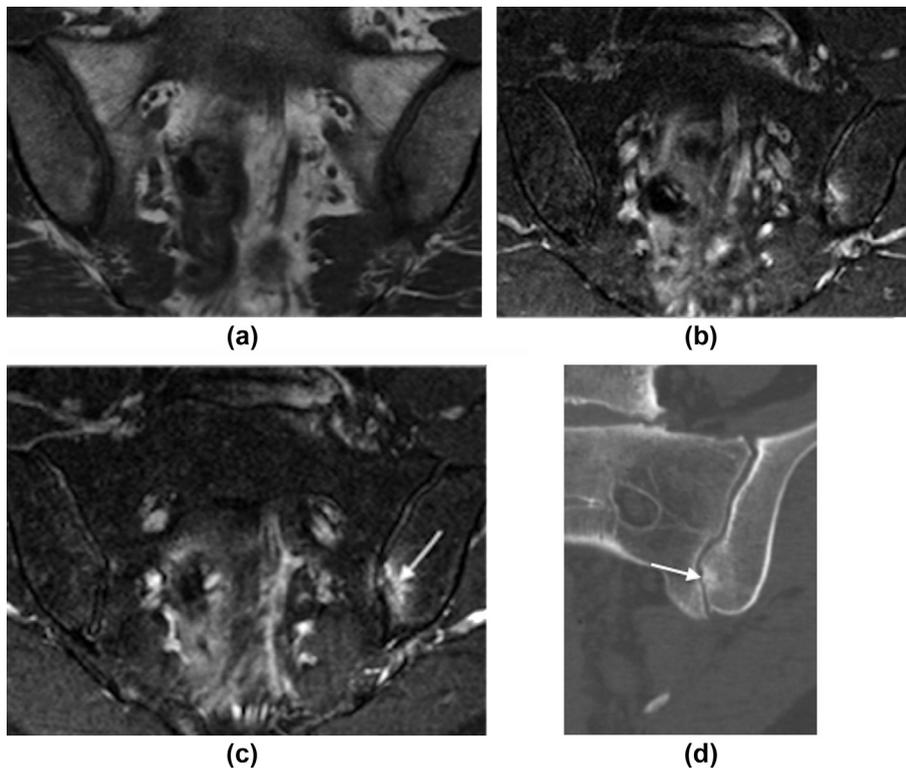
A 48-year-old female patient with inflammatory back pain, positive HLA-B27, recurrent iritis, high pretest probability of AS with semi-coronal (a) T1 (b) and (c) STIR demonstrating moderate subchondral BMO left ilium with a subtle low signal intensity line (arrow image c) in keeping with a stress fracture confirmed on a follow-up CT examination (d) demonstrating fracture (arrow) with surrounding reactive sclerosis. Patient later provided an additional history of attendance of a workout boot camp after which she developed symptoms.
